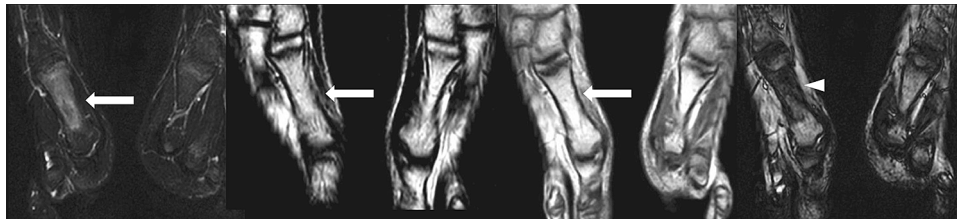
MPR reconstructions of the right and left forefoot in a 13-year-old boy. a) Increased signal in the right first metatarsal on T2 Dixon water-only image (arrow). Neither T2 Dixon fat-only image (b) nor T1-weighted image (c) show corresponding low signal (arrows). d) The out-of-phase Dixon image depicts a reduction of signal in the right first metatarsal bone compared to the left side, confirming the increased water content (arrowhead).
